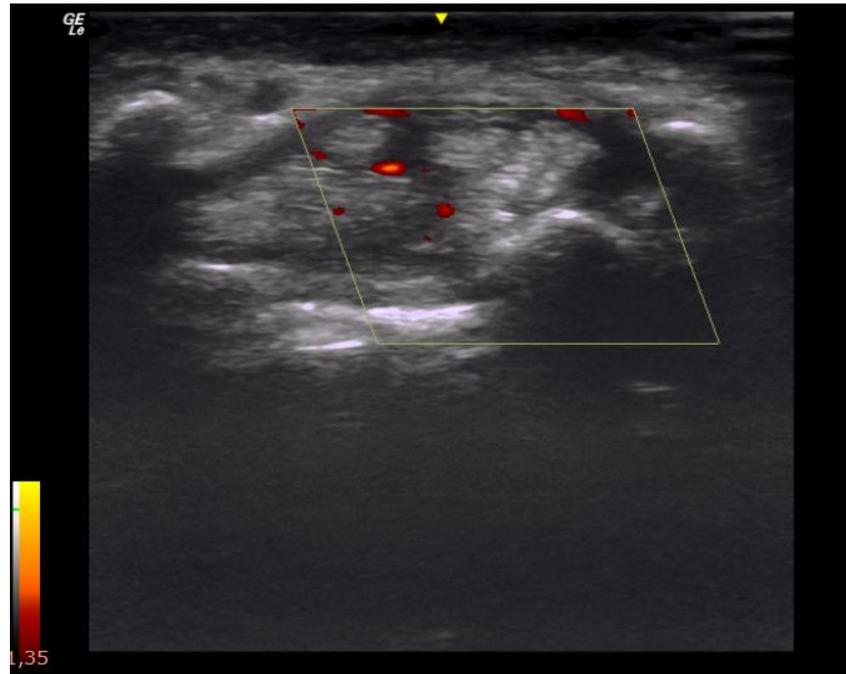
Wrist, palmar axial, showing power Doppler activity of the flexor tendons between pisiform and scaphoid bones with underlying carpal bones and flexor retinaculum roof.
